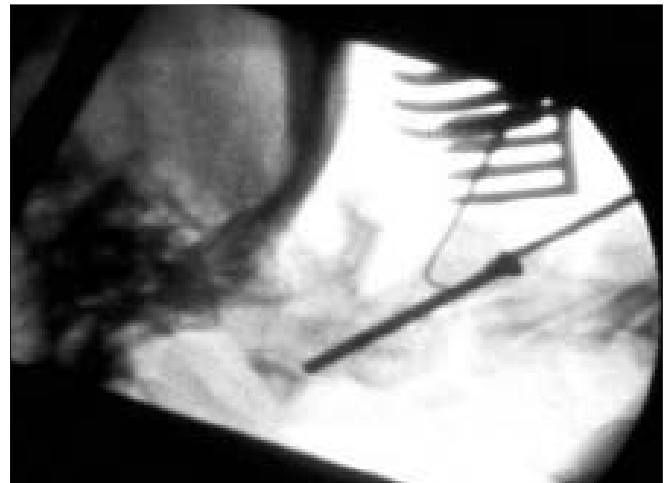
Lateral X-ray of a C1-2 transarticular screw placed over a K-wire
